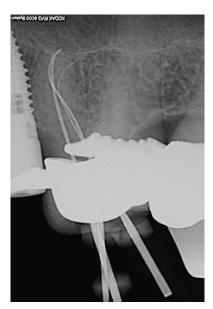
Working radiograph.
